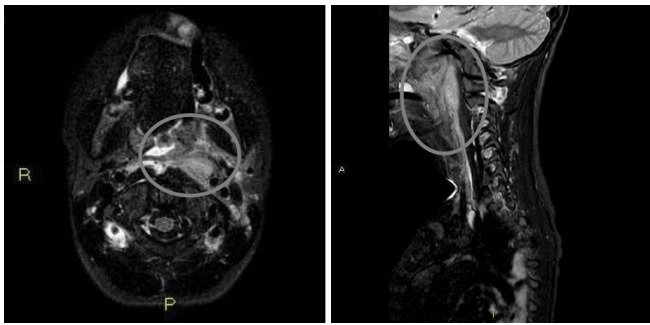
MRI imaging of interested parapharyngeal and retropharyngeal tissues.
